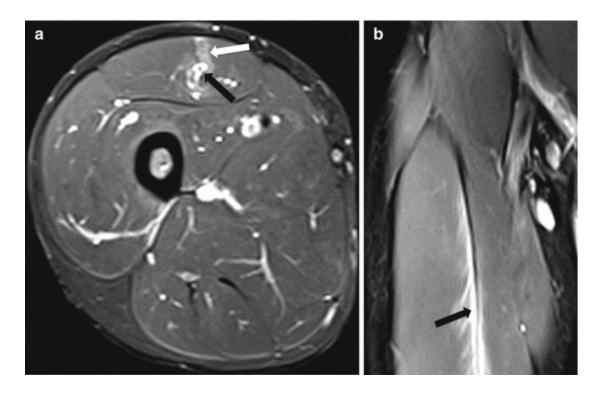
A 23-year-old male athlete with a central myotendinous injury of the deep tendon of the right rectus femoris. (a) Axial and (b) coronal fat-suppressed T2-weighted MRI show increased signal intensity around the deep tendon consistent with grade I strain (*white arrow*) with mild fluid collection adjacent to the deep tendon (*black arrow*)
